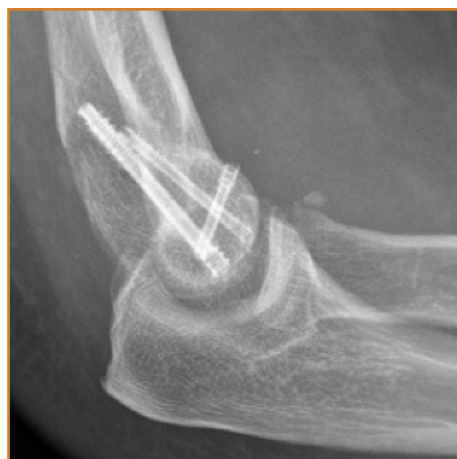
Lateral radiograph confirming anatomic reduction to the intra-articular humerus fracture with anatomic reduction and healing utilizing the two different diameters of the OsteoCentric headless compression fasteners.
